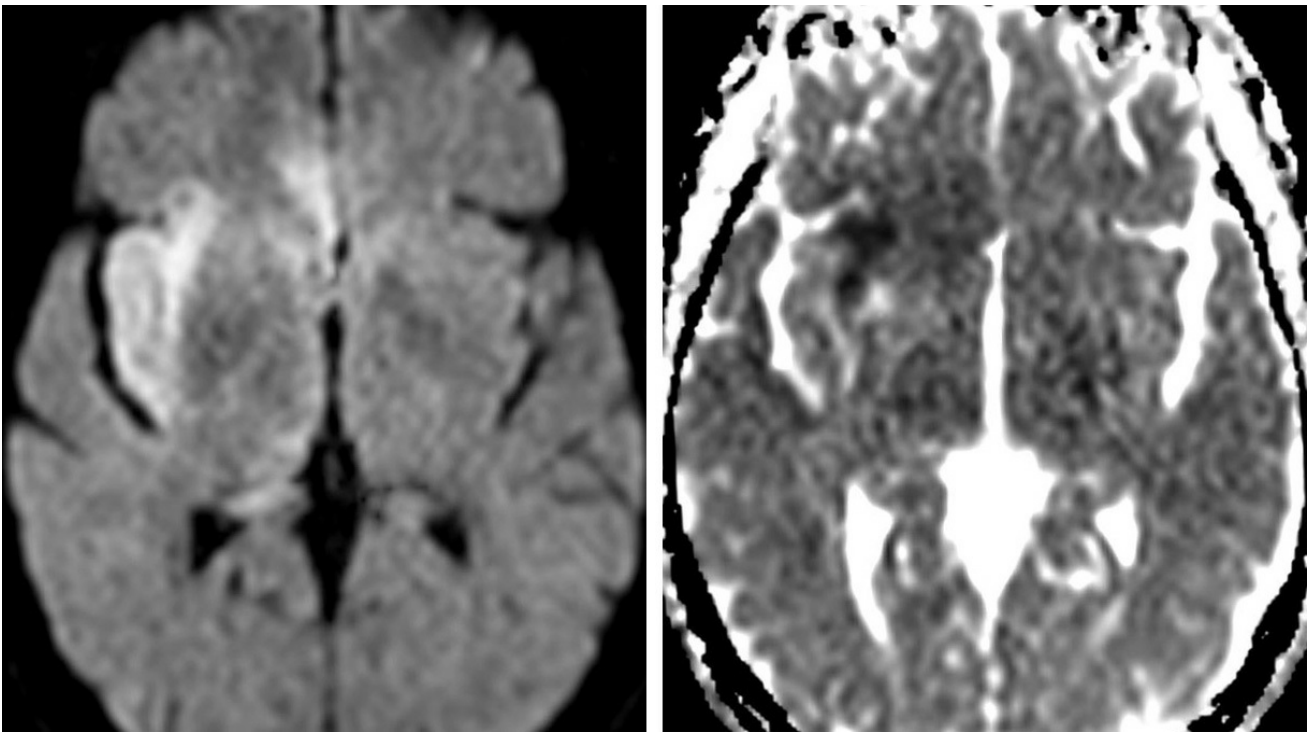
DWI (left) and ADC (right) images demonstrate restricted diffusion in the anterior right insular cortex reflecting cytotoxic edema (arrow). Vasogenic edema is also present as hyperintensity on DWI without ADC low signal intensity.
